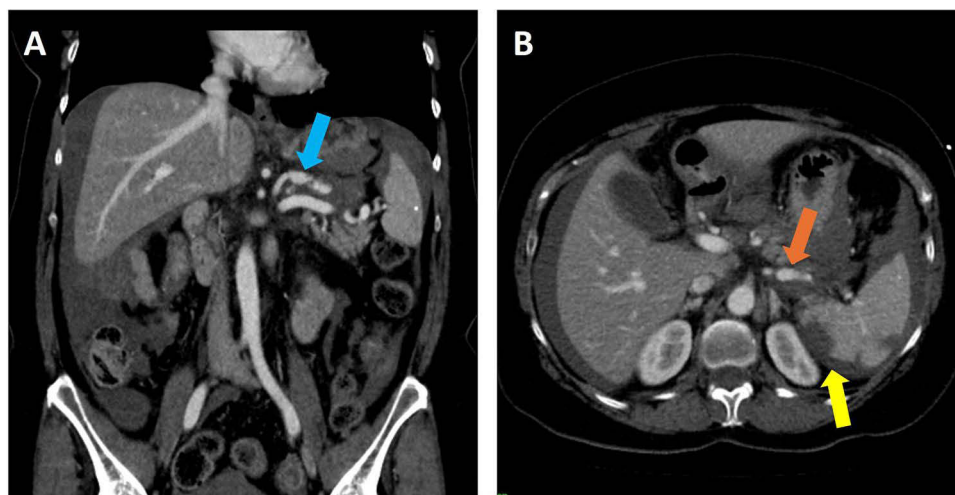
(A) Coronal reconstructed image of abdominal angiogram via CT with intravenous contrast showing irregular aneurysmal dilatation of splenic artery (blue arrow). Evidence of rupture is seen with hemorrhage in the left subdiaphragmatic and perisplenic regions. (B) Axial image of contrast-enhanced abdominal CT, which demonstrates splenic artery aneurysm (orange arrow). There are splenic infarcts seen secondary to arterial rupture with hemorrhage in the left upper abdomen (yellow arrow).
